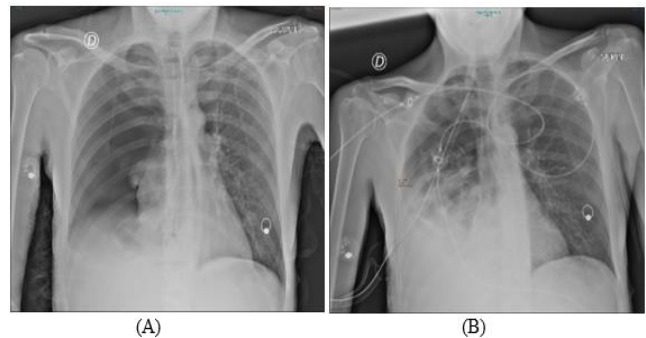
A: X-Ray showed massive right sided PNX with basal pleural effusion. B: X-Ray demonstrated the correct position of thoracostomy tube and partial re-expansion of the collapsed lung.
